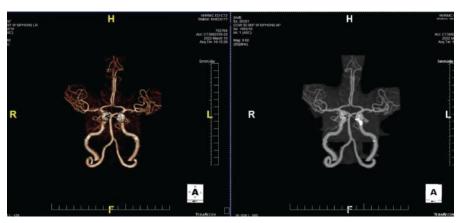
A CTA demonstrating significant plaque formation in a patient with transient visual obscurations. Note the calcification of the L>R internal carotid arteries.
